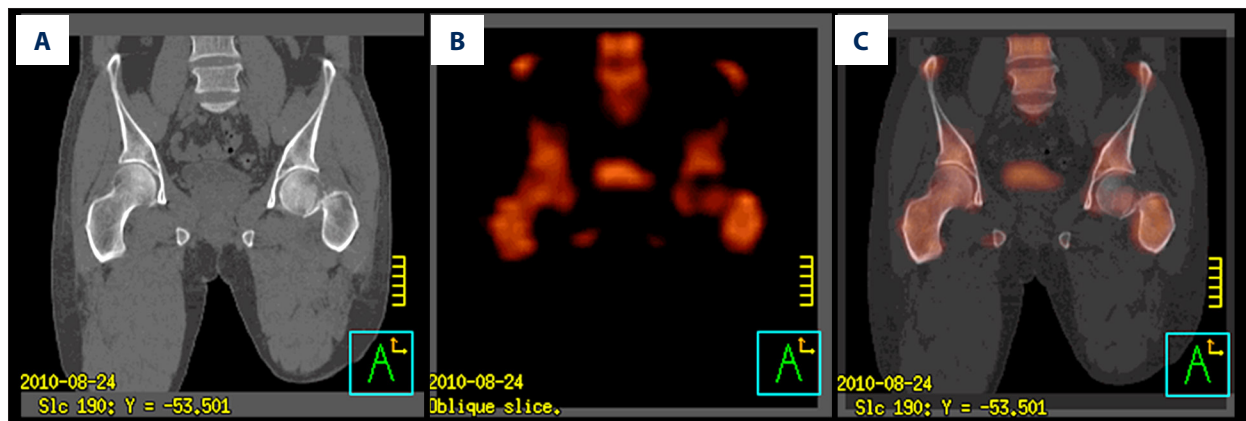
SPECT/CT images of a femoral neck fracture. (A) CT image; (B) SPECT image; (C) fused SPECT/CT image.
